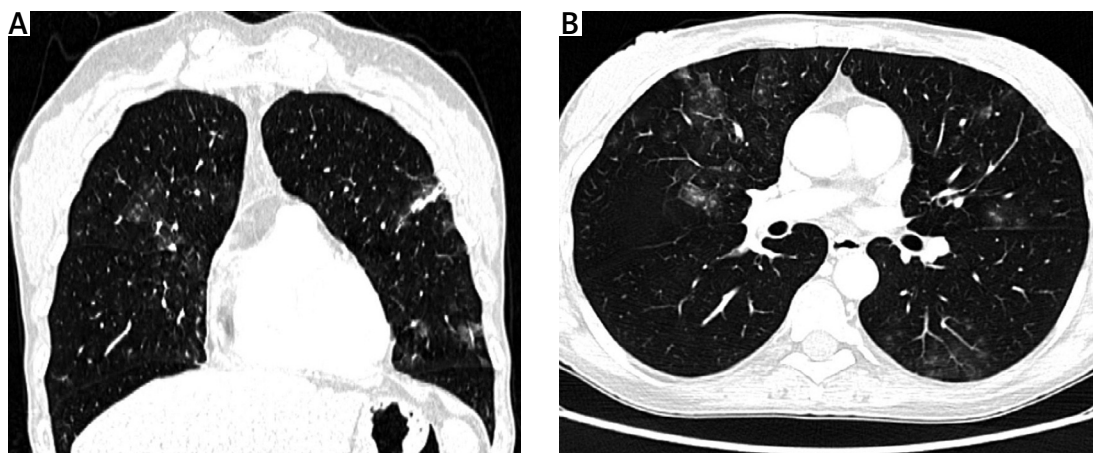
High-resolution computed tomography of the thorax (lung window) in coronal (A) and axial (B) planes showed bilateral ground-glass opacities and a few areas of consolidation, which may correspond to changes in the course of vasculitis.
